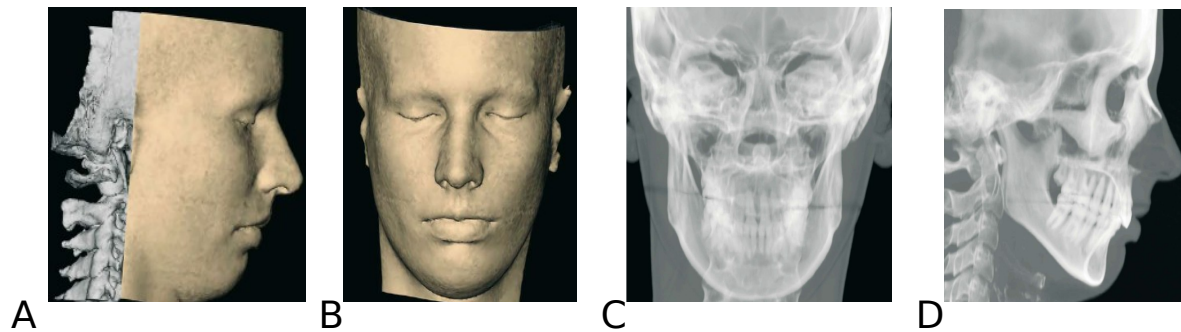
virtual volumetric lateral view (A) virtual volumetric frontal view (B) Virtual X-ray film of the skull, frontal view (D) Virtual X-ray film of the skull, lateral view(Gwen Swennen, 2006).
